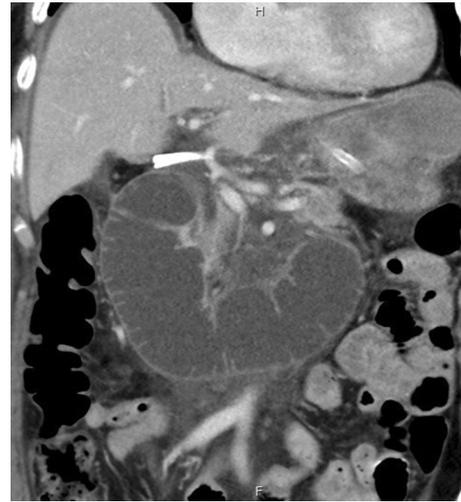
A CT scan on the sixth postoperative day of a patients undergoing gastrectomy with Billroth II reconstruction demonstrates a dilated loop of duodenum with valvulae conniventes projecting toward the lumen (key board sign) compatible with diagnosis of afferent limb obstruction
